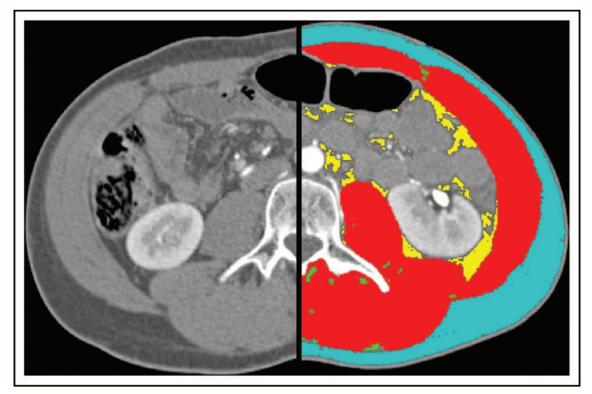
Cross-sectional image from abdominal computed tomography scan at the level of the third lumbar vertebra (L3), both unanalyzed (left) and analyzed (right) using SliceOmatic (TomoVision, Magog, Quebec, Canada). Red: muscle, green: intermuscular adipose tissue, yellow: visceral adipose tissue, and blue: subcutaneous adipose tissue.
